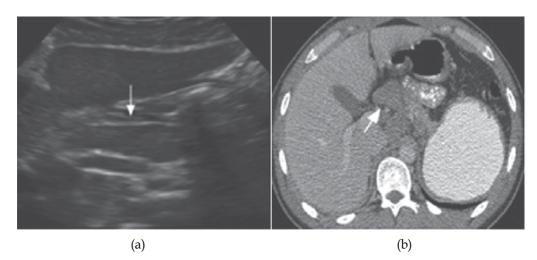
Abdominal lymphadenopathy. (a) A 34-year-old male with jaundice and systemic sarcoidosis. An ultrasonography image of the midline upper abdomen shows an enlarged lymph node (arrow) near the porta hepatis. (b) Axial contrast-enhanced CT image of the upper abdomen confirms intrabdominal lymphadenopathy (arrow).
